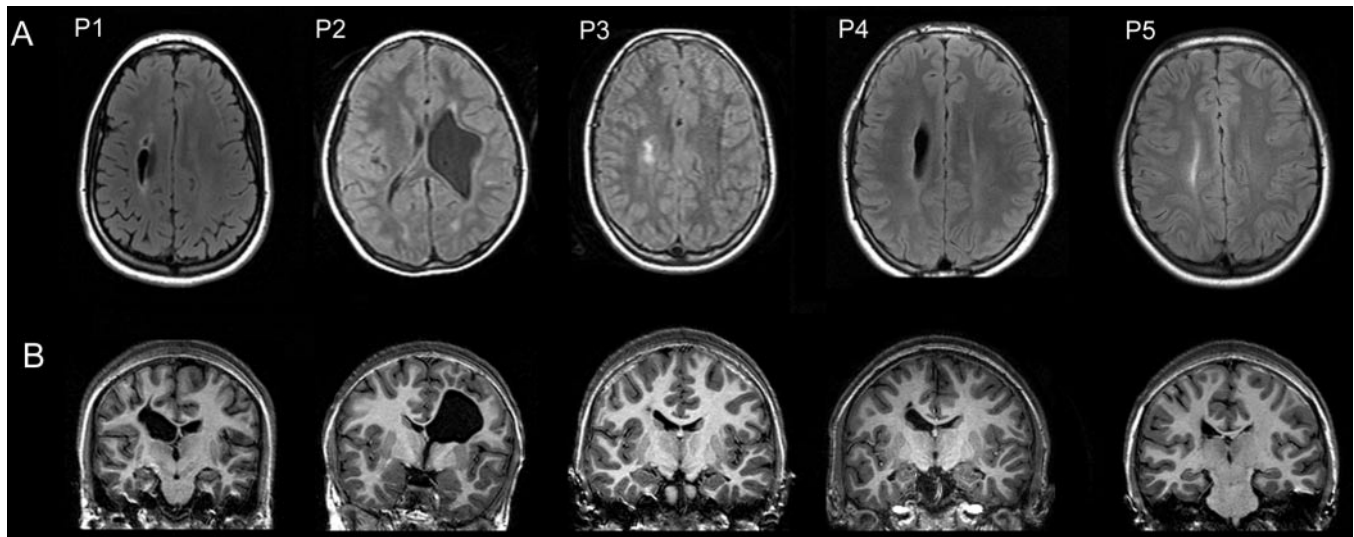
Axial and coronal MRI in patients. The representative axial images on FLAIR (A) and coronal images on T1 (B) are shown.
